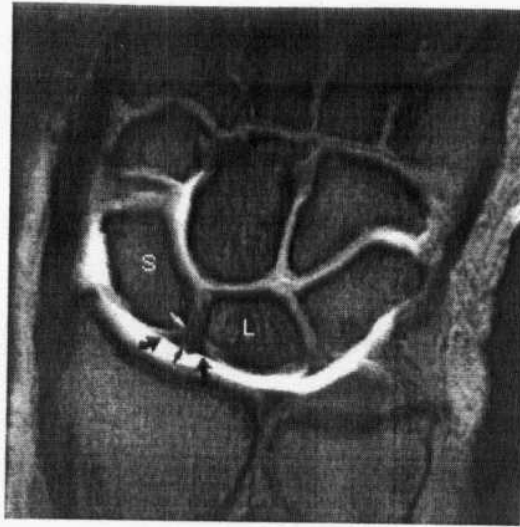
Normal variations in the appearance of the scapholunate ligament. There is intermediate signal intensity hyaline cartilage at the SL interface with the scaphoid (white arrow) and not the lunate bone. Low to intermediate linear signal intensity (black arrow) traverses both the proximal and distal surfaces of the SL ligament without tear. The proximal base of the SL ligament extends past the inflection points of both the scaphoid and lunate bones (curved arrow) (fat-suppressed T1-weighted coronal MR arthrogram). S, scaphoid; L, lunate (Quoted from Stark and Bradley, 1999).
